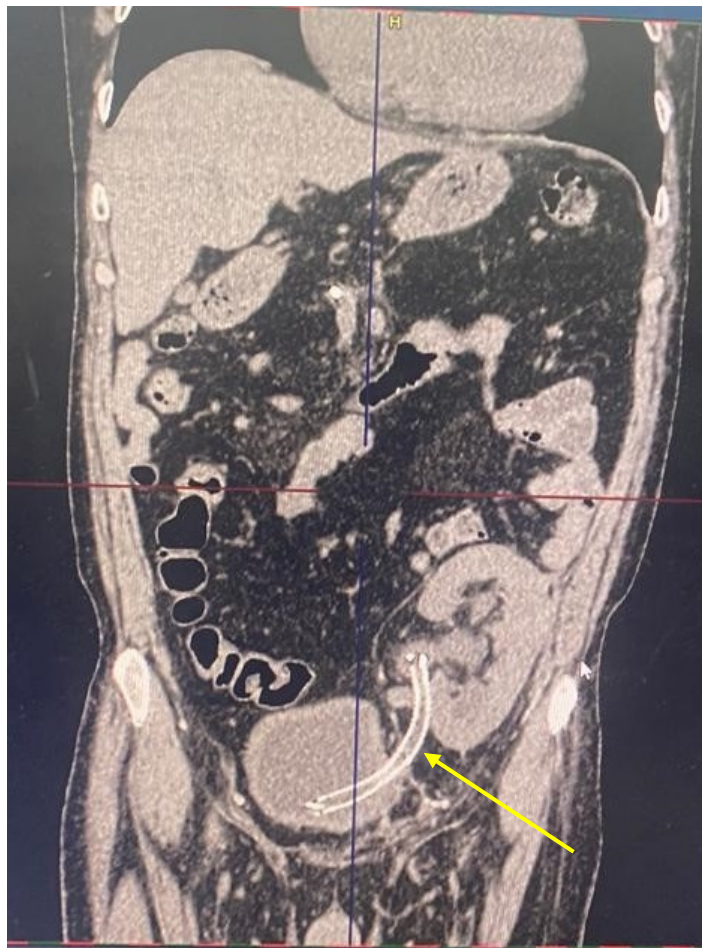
Abdominal computed tomography scan (native). Stent in the ureter of the kidney graft (yellow arrow)
